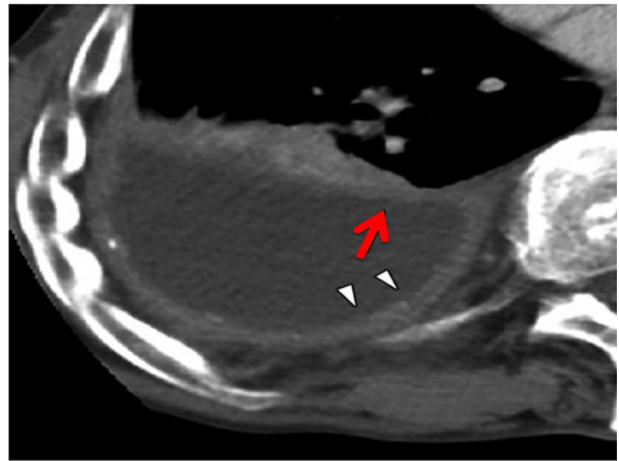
Split pleura sign—contrast-enhanced CT scan demonstrates thickening of the visceral (red arrow) and parietal pleura (white arrow heads) separated by fluid. The split pleura sign is seen mainly in empyema but may also be seen in haemothorax.
